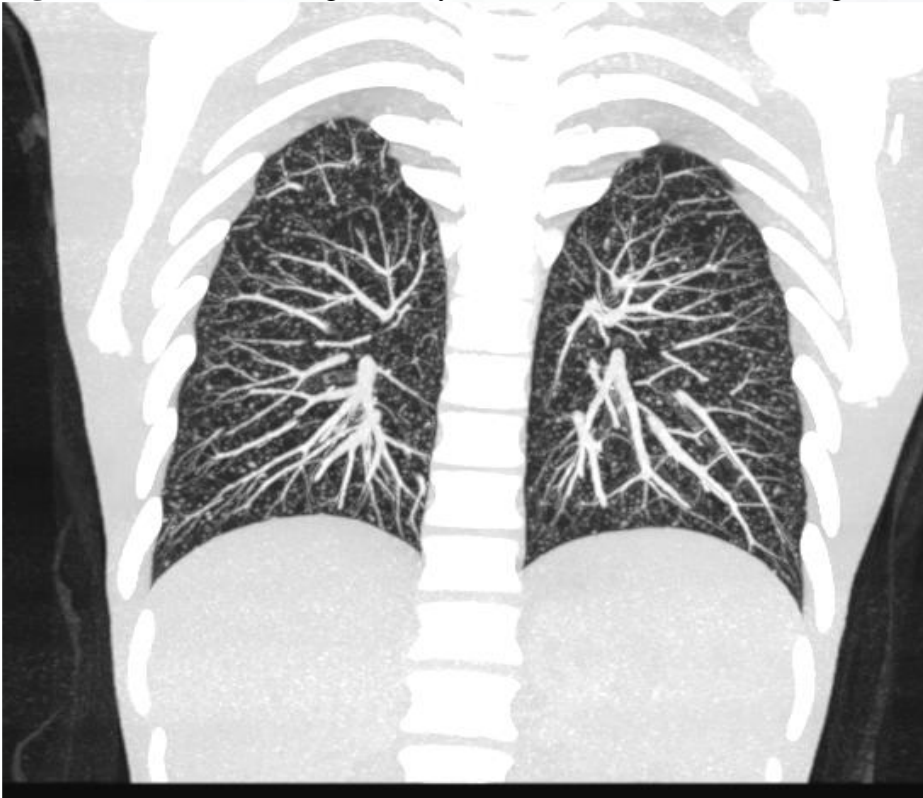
CT scan of lung : Miliary lesions was seen at coronal images.
